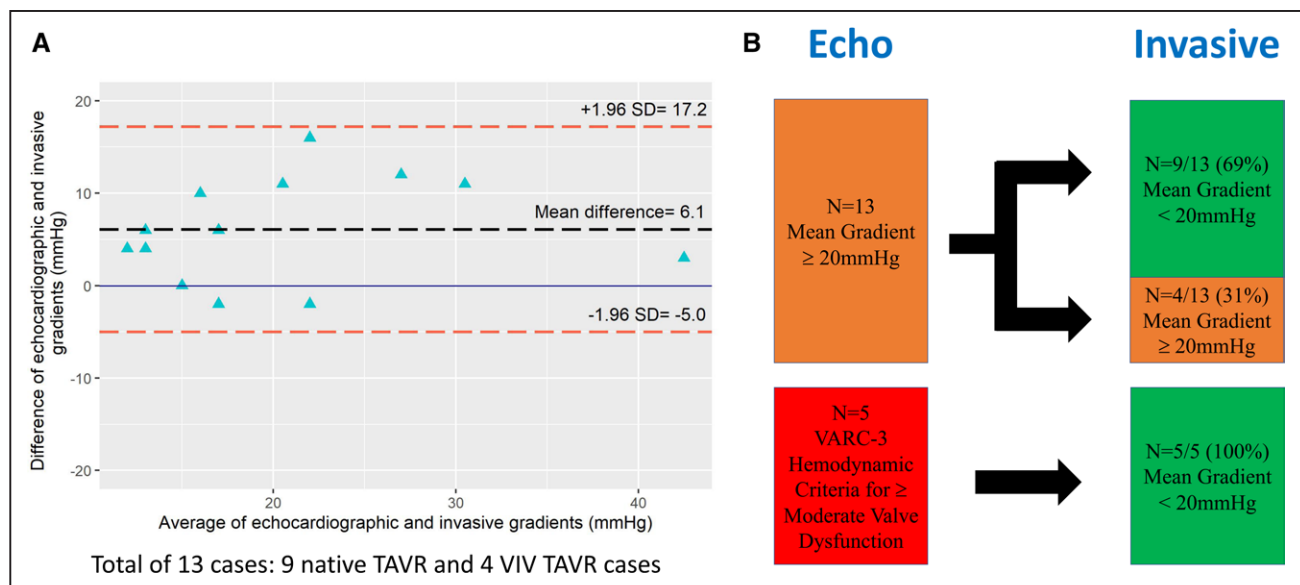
Discordance between echocardiography (echo) and standardized invasive hemodynamics (SIH).
